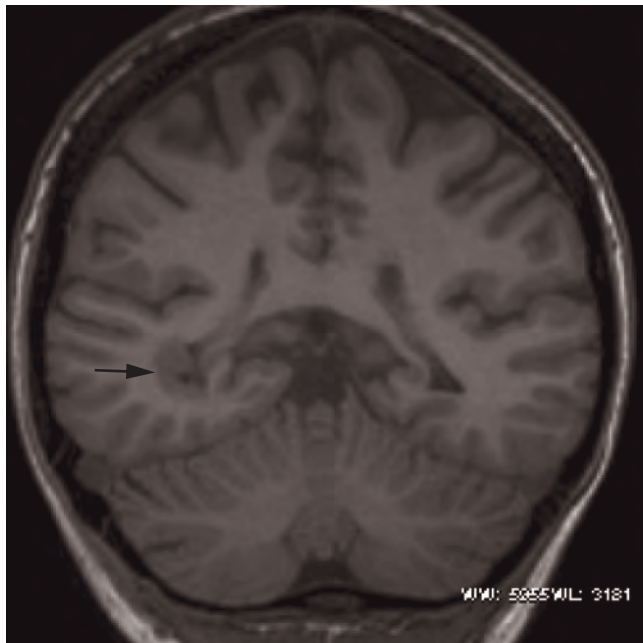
Subependymal heterotopia on the right (arrow) in coronal IR_{prep} T1-weighted image. Nodules of grey matter density are shown in the wall of the lateral ventricle.
